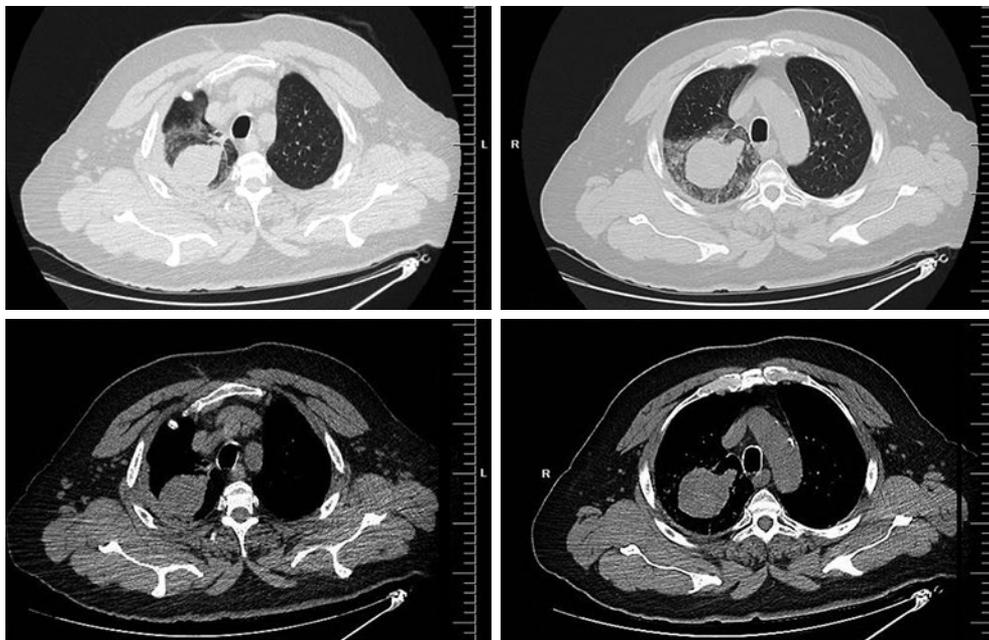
A 60×55 mm mass lesion is observed in the right upper lobe posterior segment in the thorax computed tomography axial sections, while ground-glass opacity is observed around the mass.
